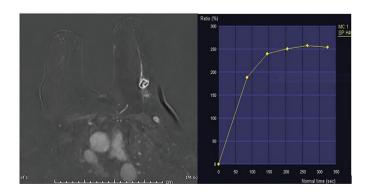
Triple negative breast cancer in 60- year-old women-Substracted T1-weighted contrast-enhanced image shows oval shape mass with circumscribed margins and rim enhancement. The lesion shows a Type 2 contrast enhancement pattern
